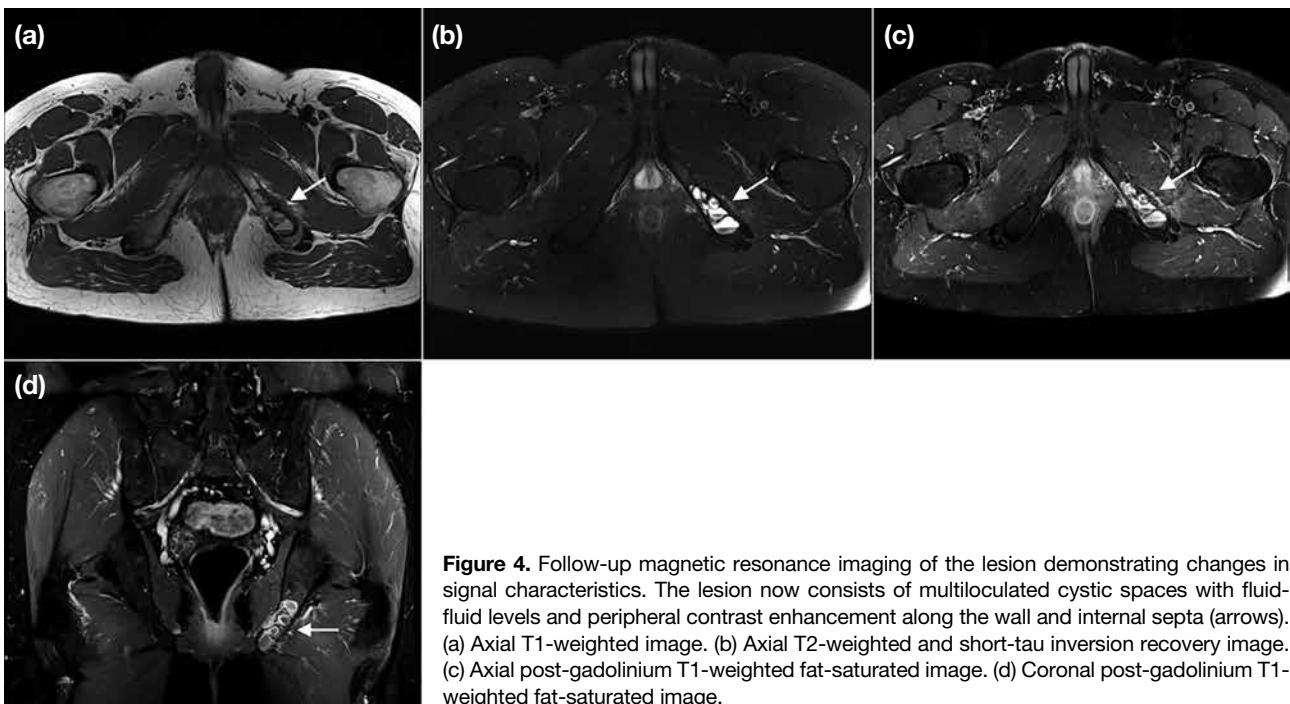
Follow-up magnetic resonance imaging of the lesion demonstrating changes in signal characteristics. The lesion now consists of multiloculated cystic spaces with fluid-fluid levels and peripheral contrast enhancement along the wall and internal septa (arrows). (a) Axial T1-weighted image. (b) Axial T2-weighted and short-tau inversion recovery image. (c) Axial post-gadolinium T1-weighted fat-saturated image. (d) Coronal post-gadolinium T1-weighted fat-saturated image.
